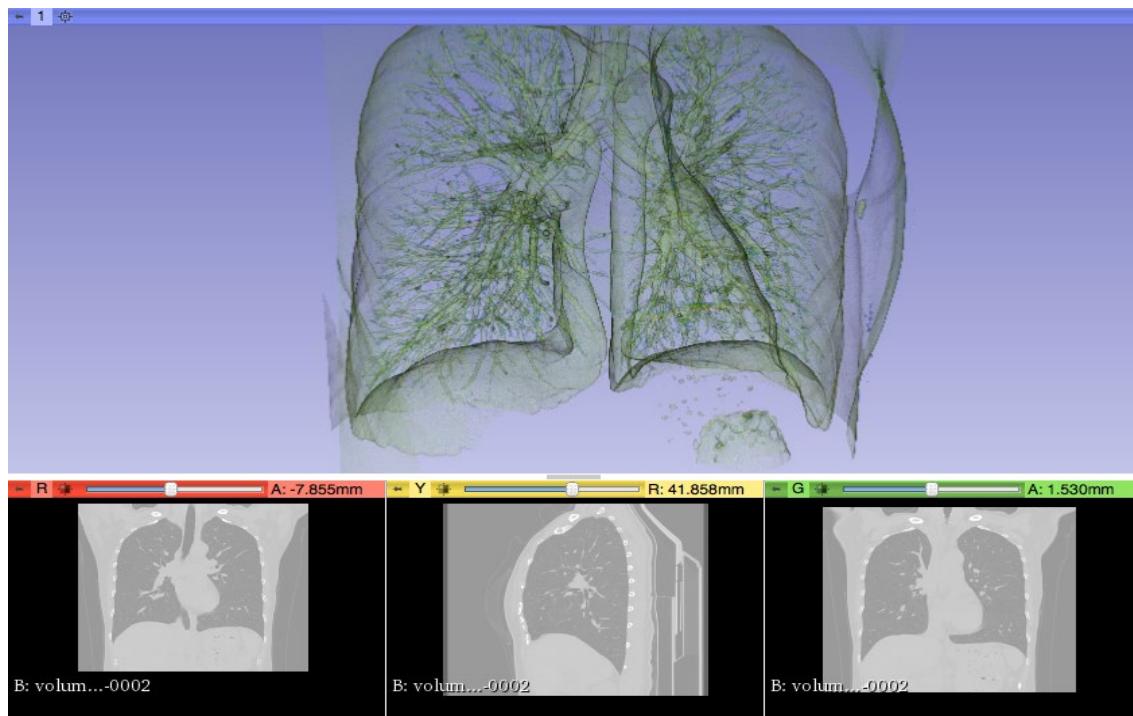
Covid Patient#02 Lung CT Scan: 3D rendering alongside 2D view of the patient lungs using 3D Slicer
